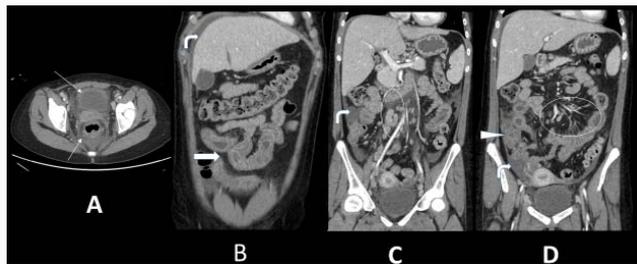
Axial (A) and Coronal (B-D) CT images of the abdomen and pelvis performed after contrast administration showed thickening of the rectal wall with adjacent inflammatory changes and questionable thickening of the bladder wall (thin white arrows-A); Small bowel enteritis with “target sign” (thick white arrow-B); Ascites (curved white arrows-B,C,D); probable duodenitis with adjacent fluid and retroperitoneal adenopathy (tall white oval C); mesenteric vasculature was engorged near the enteritis in several locations (flat white oval-D). There was some wall thickening of the cecum (white arrow head-D).
